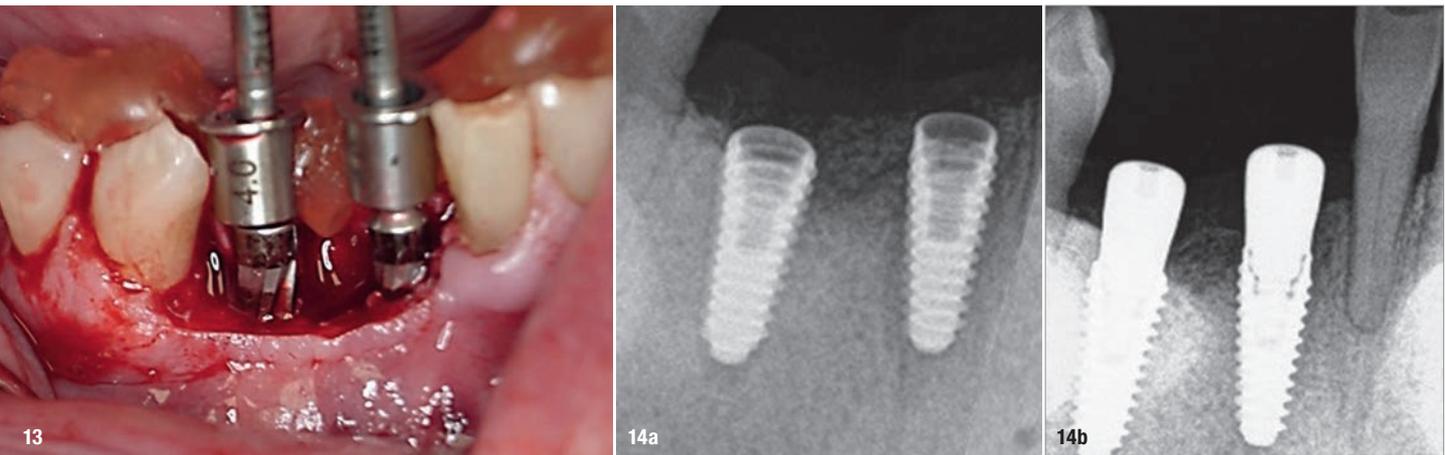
Densah osseodensification drills used through the Guide Right surgical guide to create the osteotomies for the implants to be placed. Figs. 14a & b: Periapical radiographs of the implant placement (a) and healing abutments placed (b).
